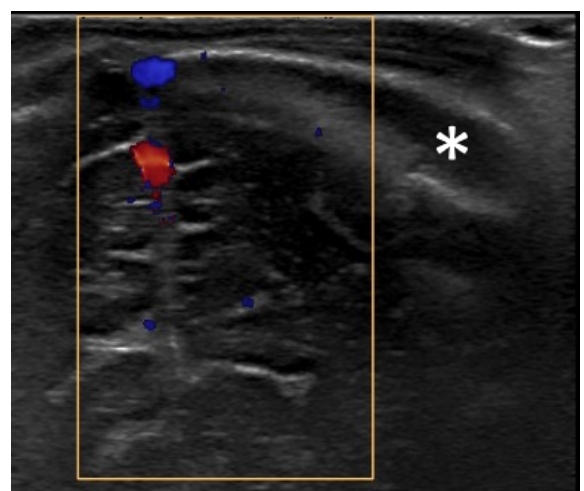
Coronal image of the brain using a high frequency linear probe with color doppler showing what appears to be an extra-axial collection (asterisk) overlying the circumvolutions of the left hemisphere of the brain.
